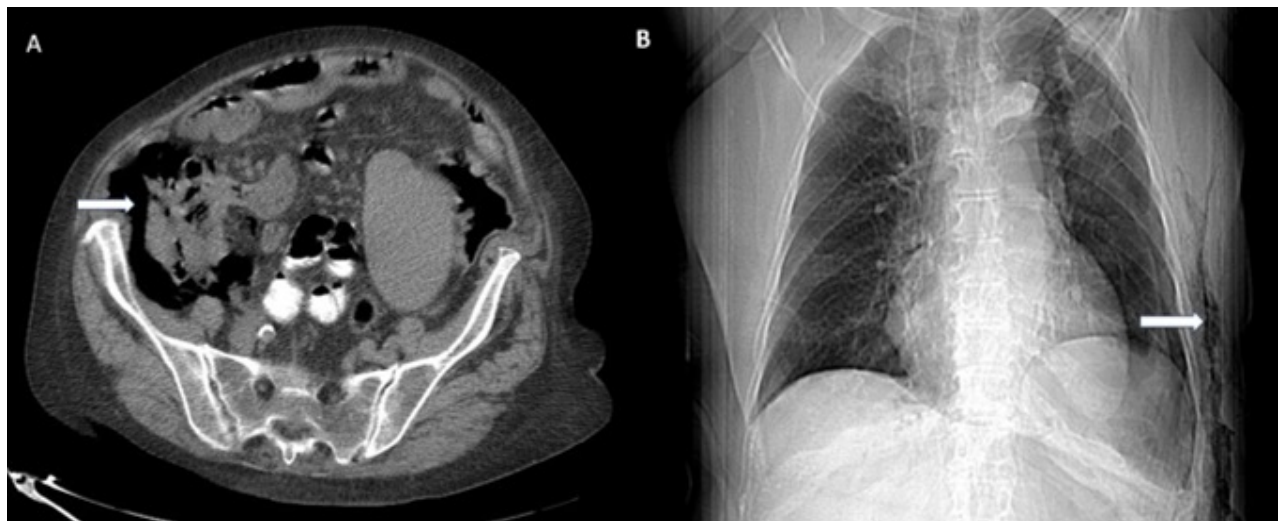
Computed tomography scan in patient 6 showing a) extensive pneumoretroperitoneum on the right side; b) subcutaneous emphysema on the left thoracic side (white arrows)
